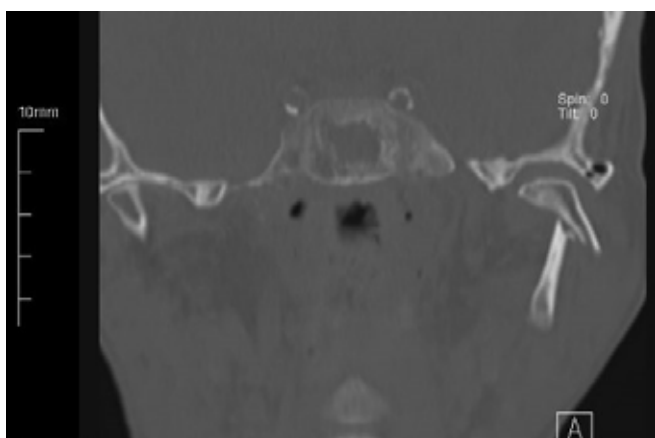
Preoperative Computed Tomography view
